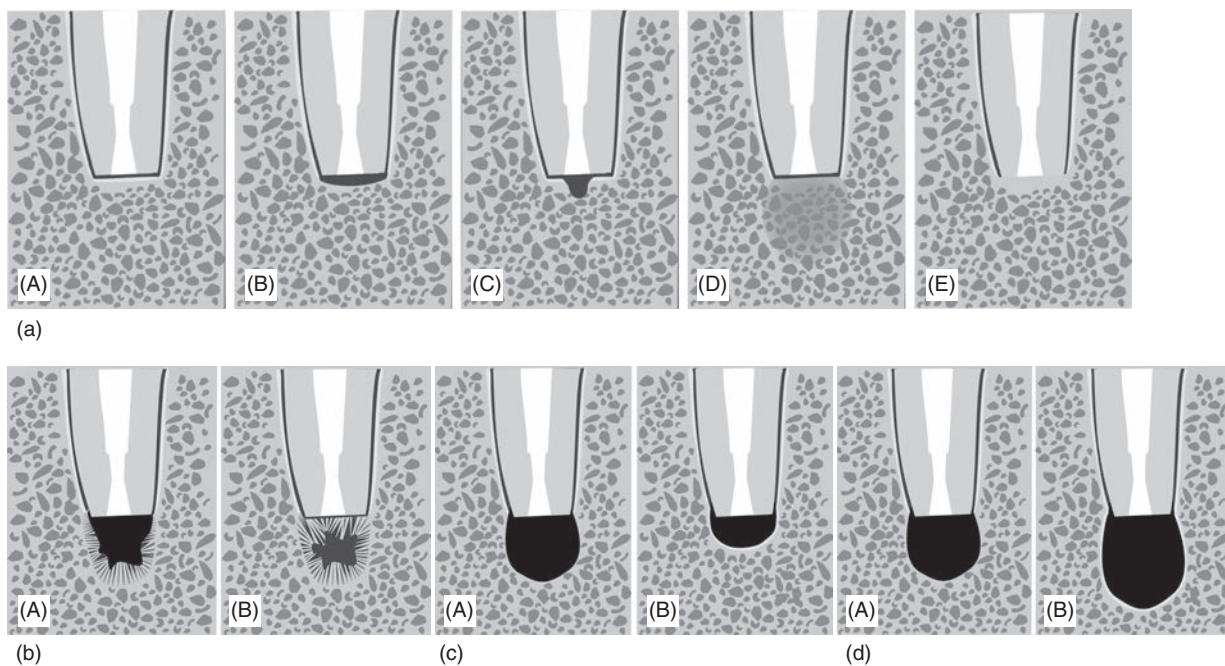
Modified pictures of Molven's radiographic classification of criteria for success. (a) Complete healing category. When the lamina dura is restored to original width (A). When the lamina dura is reconstituted but is less than two times the width along the resected root surface (B). When the lamina dura is widened along the root end filling material (C). Complete bone repair, but the density of bone in the surgical site is not the same as the surrounding bone (D). No discernible lamina dura or pdl at the resected root surface, suggesting ankylosis. (b) Incomplete healing category (scar tissue). The radiolucent area at follow-up has decreased but there is a dense radiolucency that is asymmetric to the apex and has a dense compact border often with a sun burst bone pattern (A). A dense radiolucent area not in continuity with the pdl within the surgical site (B). (c) Uncertain healing category. Here (A) represents the radiolucency as seen on an immediate postoperative radiograph and (B) represents the follow-up. The area has reduced significantly but is still larger than two times the original pdl space. (d) Unsatisfactory healing category where (A) represents the radiolucency as seen on an immediate postoperative radiograph and (B) represents the follow-up. The area has enlarged in size or remains the same.
